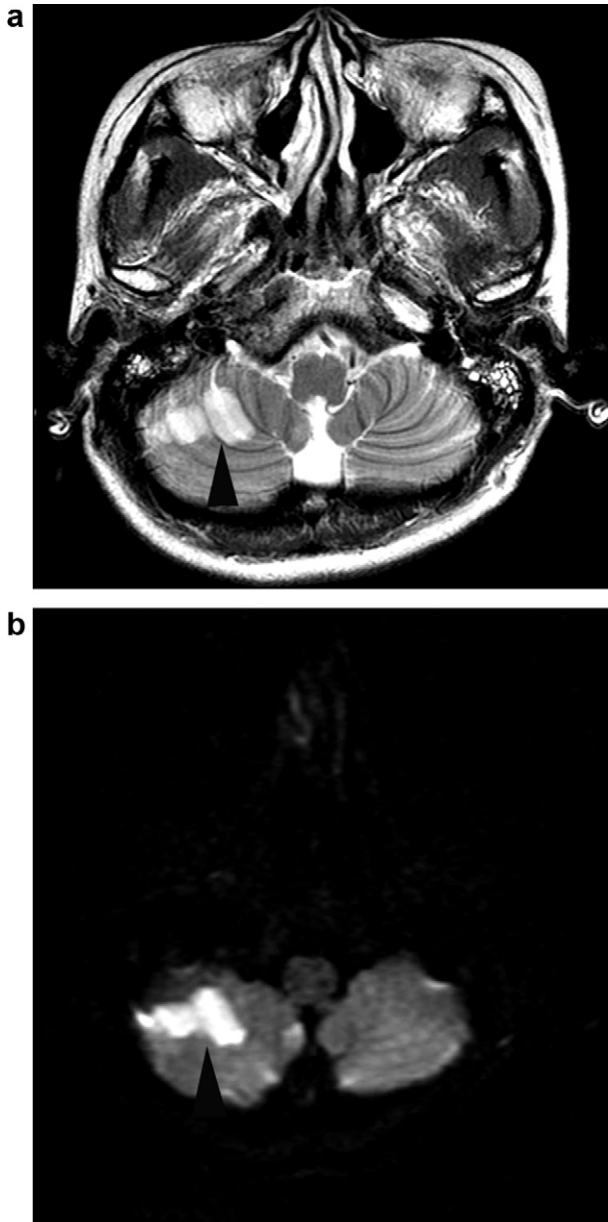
Brain magnetic resonance imaging (MRI) scans. Axial T2-weighted brain MRI revealed a hyperintense area in the right cerebellar hemisphere (a). Diffusion-weighted brain MRI showed a hyperintense focus in the same area as a (b).
